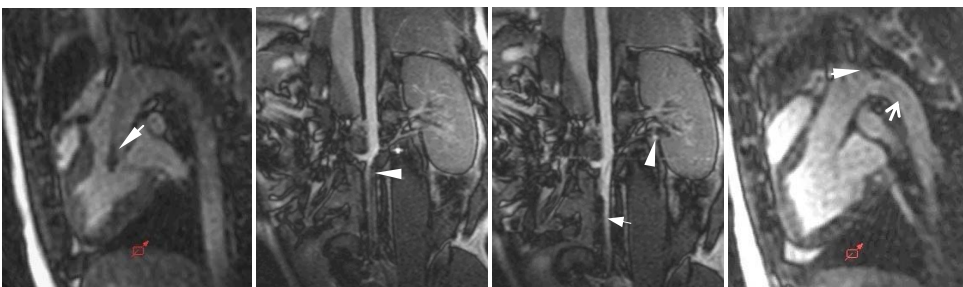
On Real-time MRI, the artifacts induced by the iron markings (arrowheads) are clearly depictable in the left ventricle (a), within the aorta (b), the renal (c) and carotid (d) arteries. Additionally, the artifacts induced by the iron doped core material (arrow in sub-picture (d)) can be delineated.
